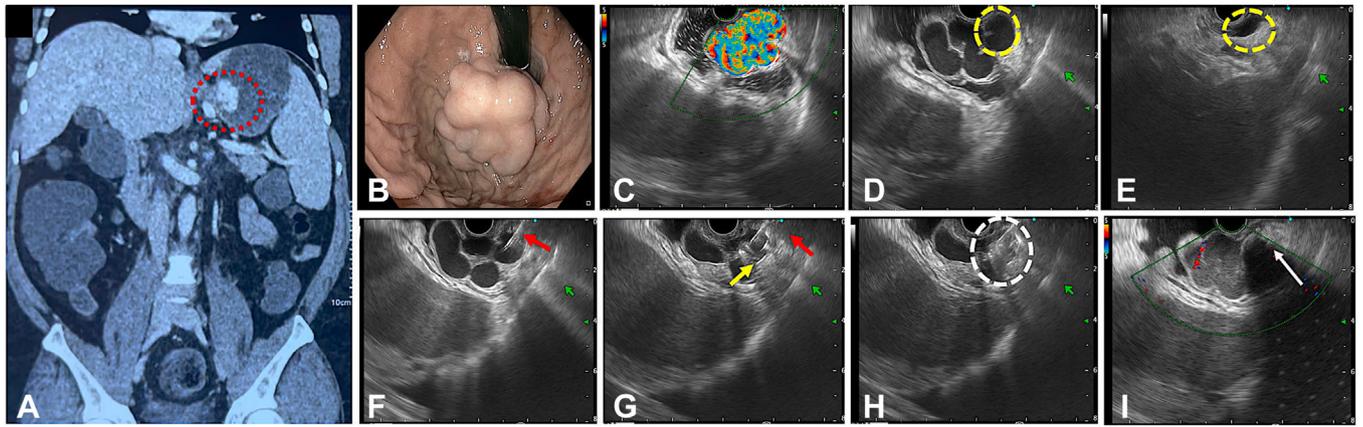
EUS-guided embolization of the gastric varices by embolizing feeder vessels. A, Coronal section of contrast-enhanced CT scan of the abdomen showed large fundal varices with perigastric collateral (*dotted red circle*). B, Endoscopic view of large gastric varices. C, EUS image showing strong Doppler flow within the large gastric varix. D, EUS image showing the gastric varix was formed by a single large feeder vessel (*dotted yellow circle*; Arakawa type I). E, Extramural part of the feeder vessel was traced (till splenic vein in majority) on counterclockwise rotation and confirmed (*dotted yellow circle*). F, Feeder vessel was punctured with a 19-gauge needle (*red arrow*). G, Coils (hyperechoic rings, *yellow arrow*) were deployed into the varix. H, Glue was injected. EUS image shows coil–glue cast complex (*dotted white circle*). I, Complete thrombosis with obliteration of gastric varix, with shadowing from the coil–glue complex seen (*white arrow*).
